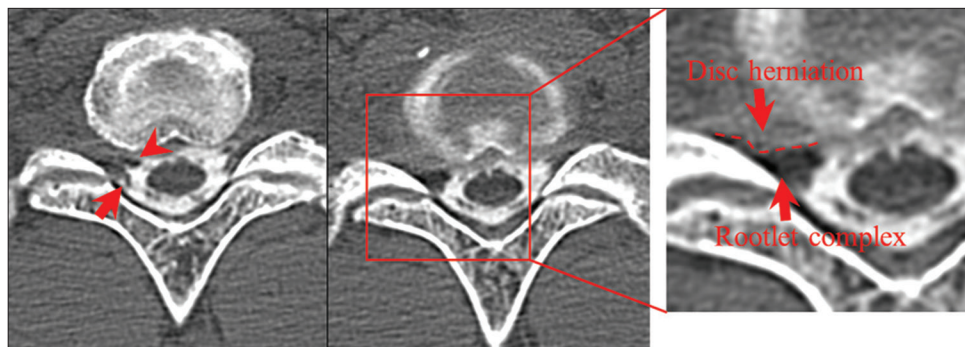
Horizontal section of computed tomography myelogram showing contrast-enhanced defects contributed by rootlet stagnation (arrowhead: ventral rootlet and arrow: dorsal rootlet). In this representative case, the disk contrast and rootlets complex could be clearly differentiated based on the density of CT images.
